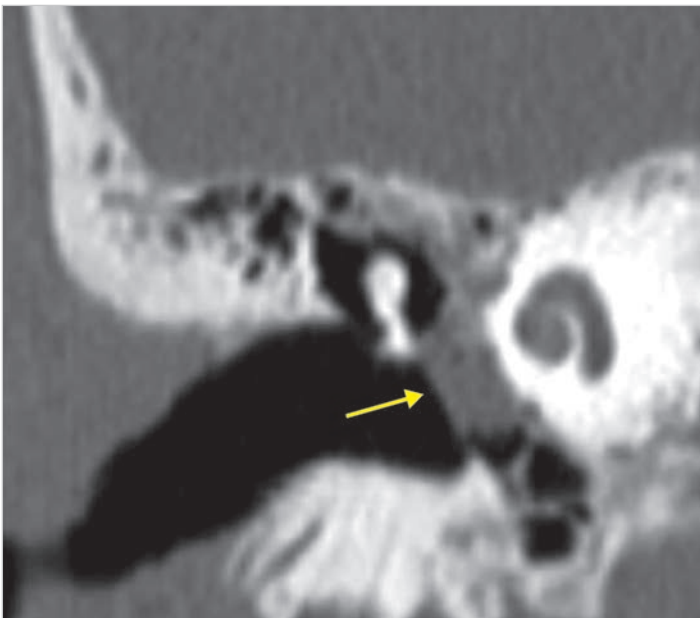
CT scan of the right ear of the same patient, coronal view. The cholesteatoma pearl is clearly visible medial to the malleus (arrow).
